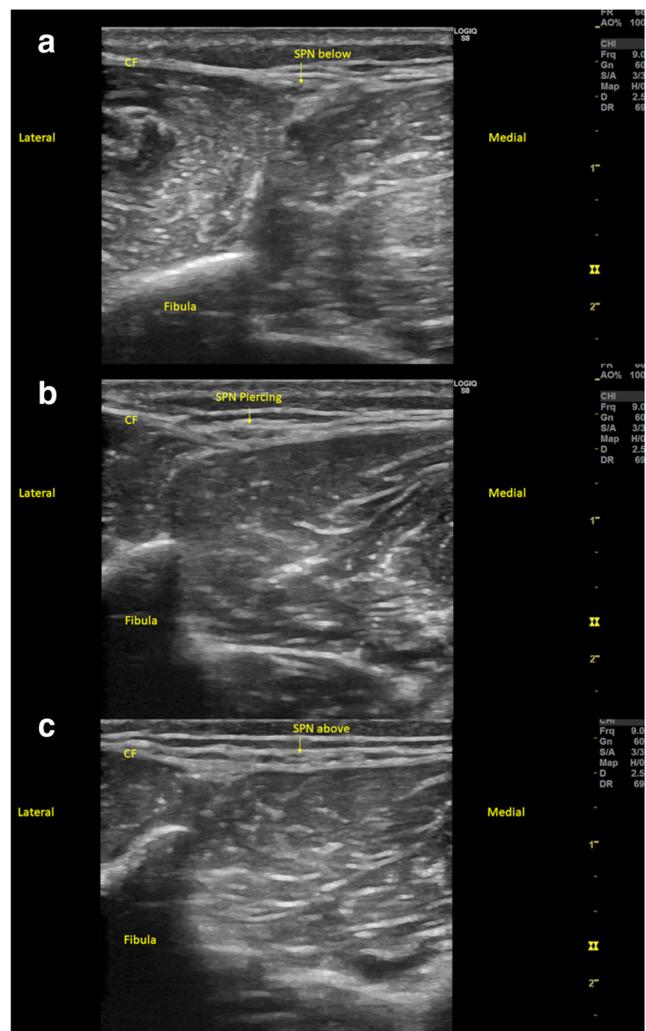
In image a, the superficial peroneal nerve (SPN) is below the crural fascia in the lower limb. Image b shows the superficial peroneal nerve as it pierces the crural fascia in a sonographic short-axis view. Image c shows the superficial peroneal nerve above the crural fascia in a sonographic short-axis view
